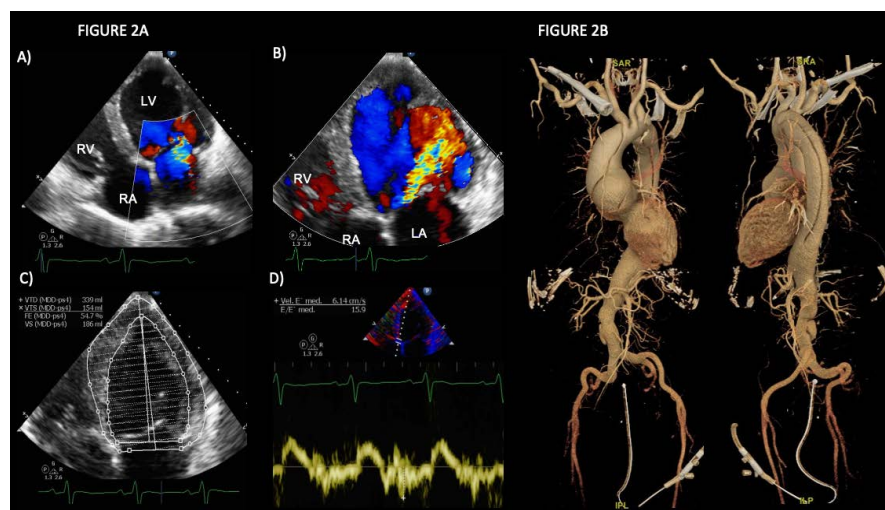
(A) Transthoracic echocardiography. A) Moderate mitral regurgitation (pressure half time 29.29 ms). B) Severe aortic regurgitation (pressure half time 163 ms, vena contracta 8.5 mm). C) LV eccentric hypertrophy (RWT-0.35, LVMI-290 gr/m²) with an ejection fraction of 54.7%. D). left ventricular end-diastolic hypertension. (B) Coronary computed tomography angiography. 3D-CCTA shows a dissection flap from the sino-tubular junction to T12, extending towards the proximal third of the brachiocephalic trunk; with a second dissection flap in the infrarenal aortic segment, with extension from L4 to S1; as well as an aneurysmal dilation of the aortic root (76 mm), sinuses of Valsalva (69 mm), sino-tubular junction (80 mm), ascending aorta (81 mm), and from the isthmus to the origin of the superior mesenteric artery (47 mm) at the level of T12 and inferior vena cava. Abbreviations: RV: right ventricle; LV: left ventricle; RA: right atrium; LA: left atrium; RWT: relative wall thickness; LVMI: left ventricular mass index.
